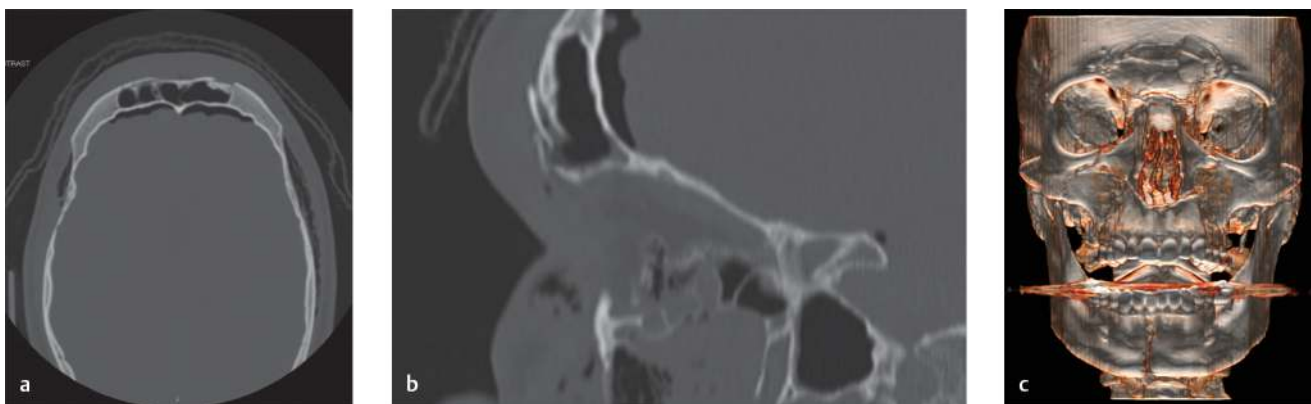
(a–c) Computed tomography (CT) scan of a patient with comminuted anterior frontal sinus fractures. Posterior table component was minor and no nasofrontal outflow tract (NFOT) obstruction was noted intraoperatively, so the patient was treated with open reduction internal fixation (ORIF) of anterior table with several low-profile plates.
